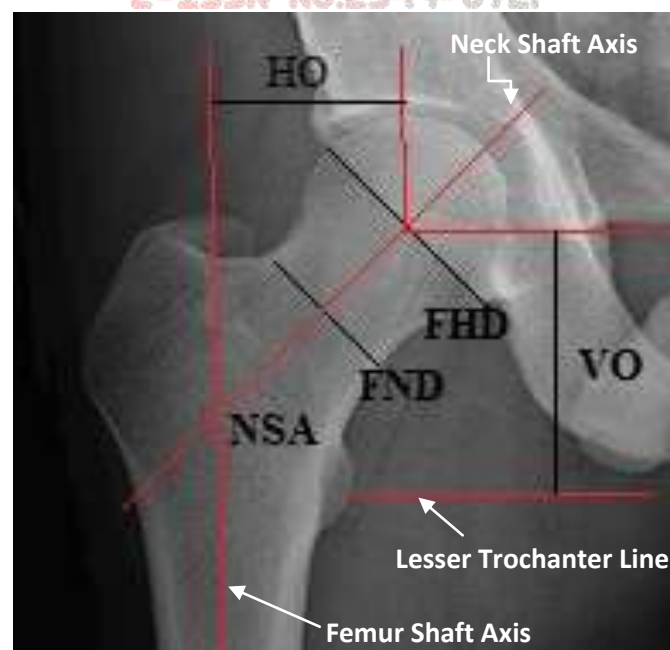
Position of anatomical parameters measured from the radiograph
